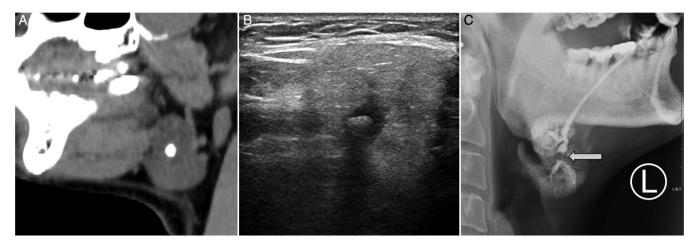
(A) Sagital computed tomography view and (B) ultrasonography showed a intraparenchymal stone in Wharton's duct. (C) On sialogram of the left Wharton's duct (L), the stone appeared as a filling defect (white arrow) in the intraglandular duct (type III).
